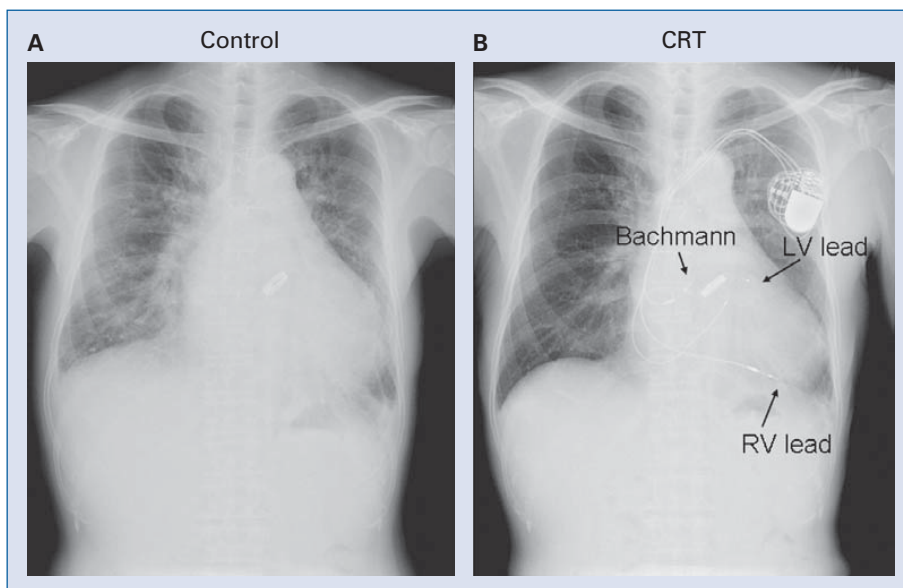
Chest X-ray shows an improvement of congestive heart failure before (A) and after (B) cardiac resynchronization therapy and Bachmann’s bundle pacing implantation; RV — right ventricle, LV — left ventricle.
